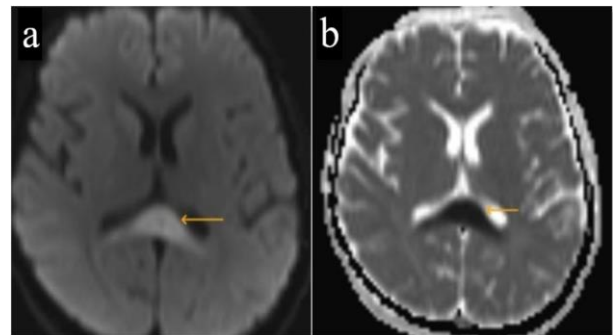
Magnetic resonance imaging (MRI) - diffusion-weighted imaging (DWI) sequence (a) and apparent diffusion coefficient (ADC) sequence (b) showing restricted diffusion (yellow arrows) in the splenium of corpus callosum indicating grade 2 diffuse axonal injury (DAI).
